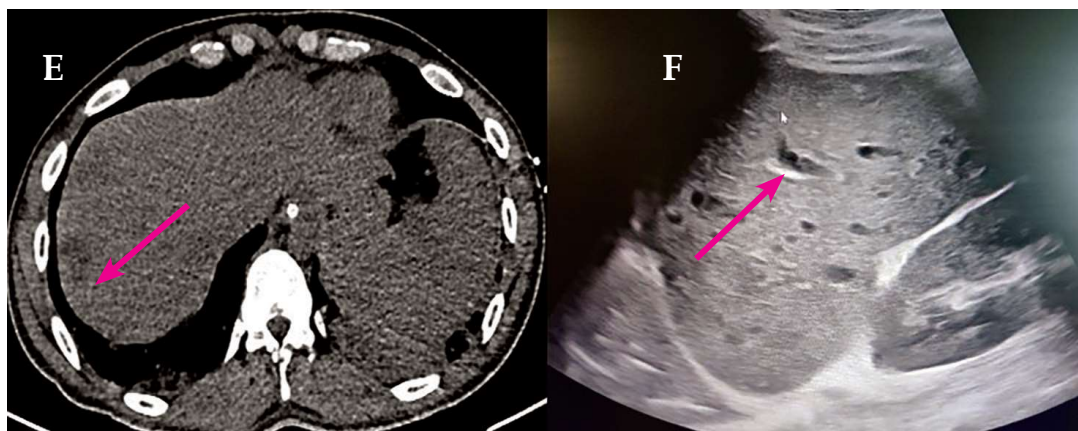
(E) CT abdomen showed few hypodense lesions in liver suggestive of micro-abscesses, (F) Ultrasound abdomen showed few micro-abscesses in spleen
